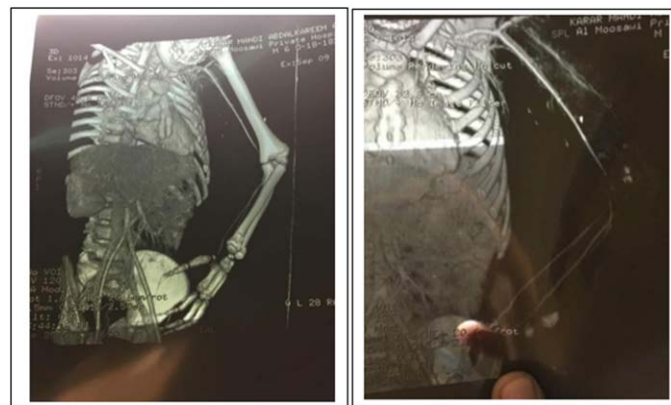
Brachial artery injuries in multislice CT-A, (Lesions < 5 mm) for another patient.
